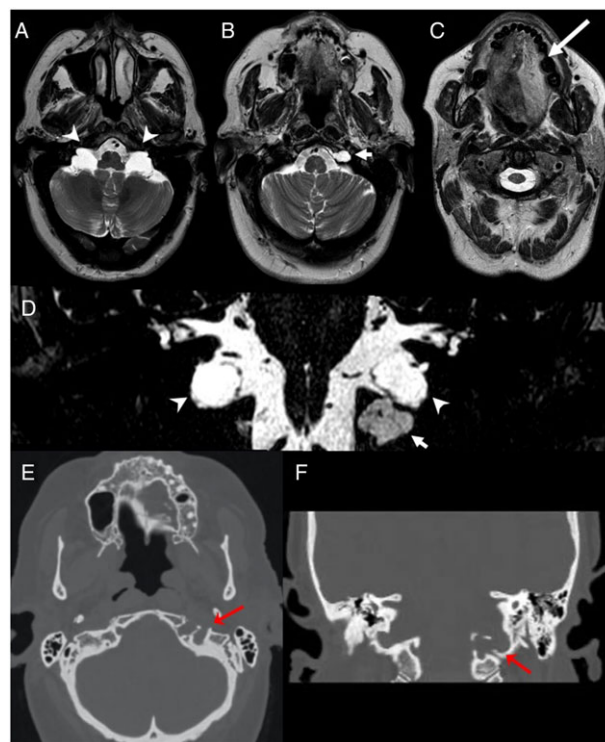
Axial T2-weighted imaging (A–C) and coronal FIESTA MRI (D) show bilateral arachnoid cysts in cerebellopontine angles (arrowheads) and left intradiploic meningocele (short arrow). Note the T2 hyperintensity of left tongue (long arrow) suggesting subacute denervation. Axial (E) and coronal (F) non-contrast CT scan show intradiploic extension along hypoglossal canal (red arrows).
